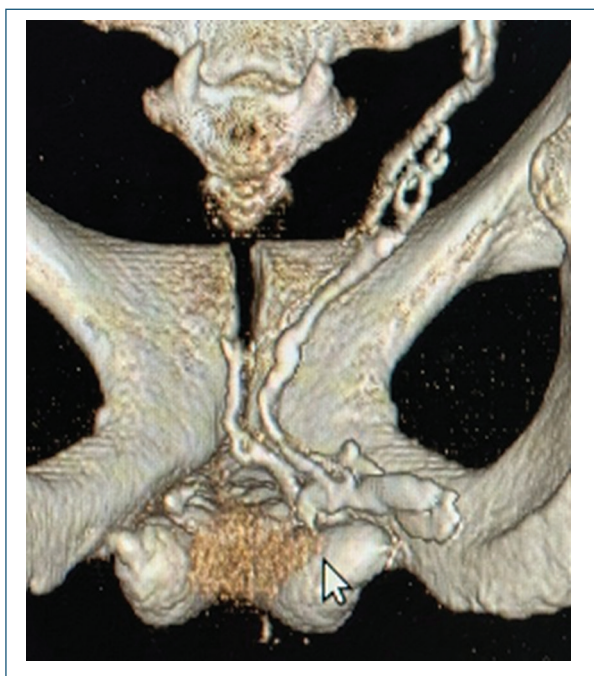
Deep dorsal venous leakage to the Santorini plexus on computed tomography cavernosography.
